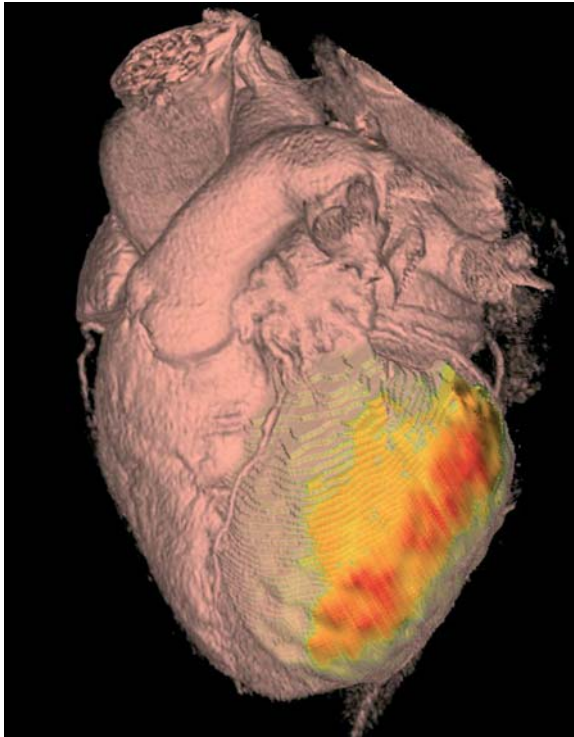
A 78-year-old male patient with three-vessel coronary artery disease. PET/CT imaging was performed by acquiring contrast-enhanced CT data and [^{13}N]ammonia PET at rest and stress. The figure displays a fused volume-rendered 3-D image of the CT data and the PET flow information. The area in *red* indicates a reduced flow reserve, characteristic of ischemia due to a high-grade stenosis in the left circumflex coronary artery
